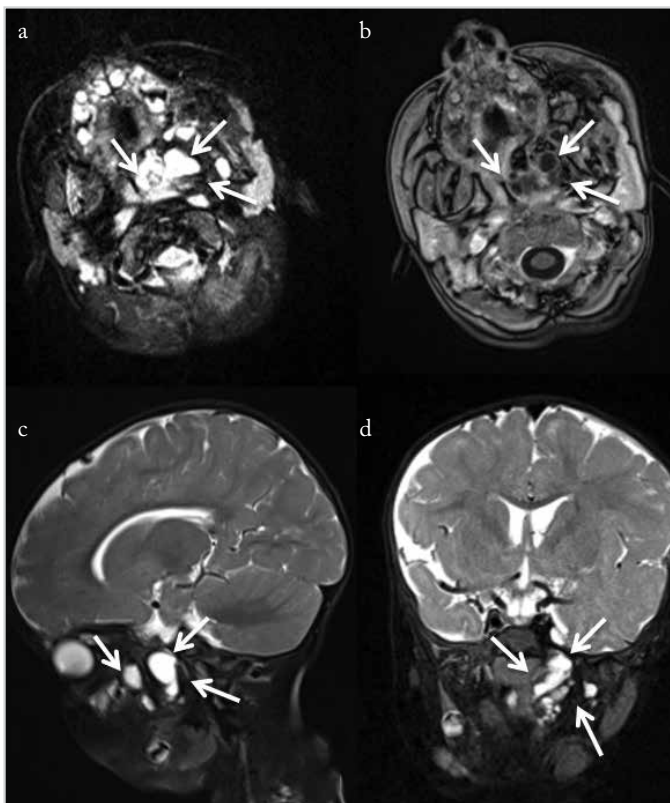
a-d. Multiloculated dominantly cystic lesion on the left parapharyngeal space was revealed on a T2-weighted axial plane (a), sagittal plane (c), and coronal plane (d). No contrast enhancement was detected on T1-weighted axial image (b)
